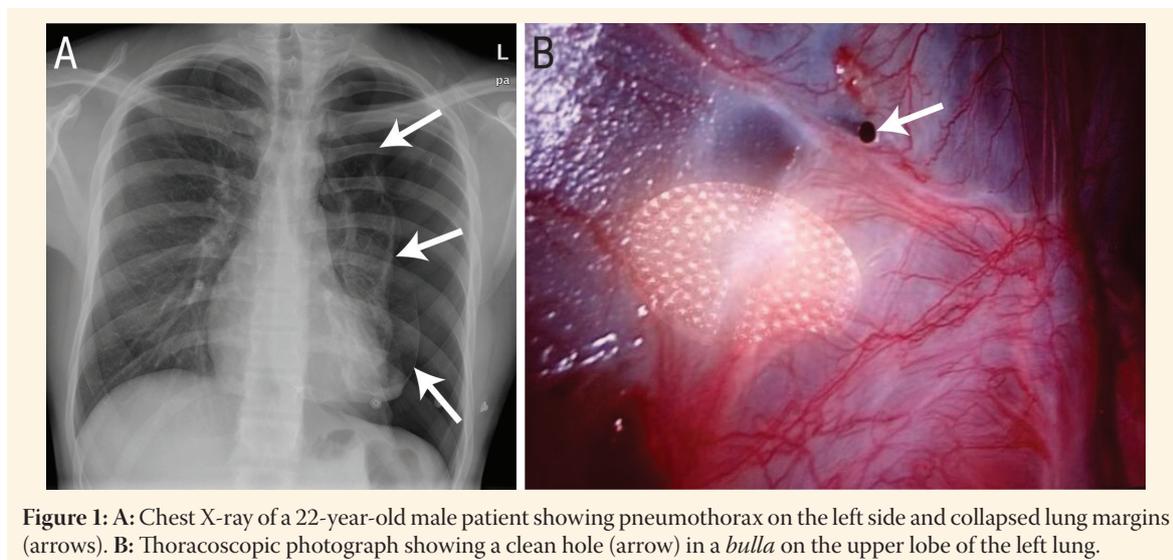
A: Chest X-ray of a 22-year-old male patient showing pneumothorax on the left side and collapsed lung margins (arrows). B: Thoracoscopic photograph showing a clean hole (arrow) in a *bulla* on the upper lobe of the left lung.
